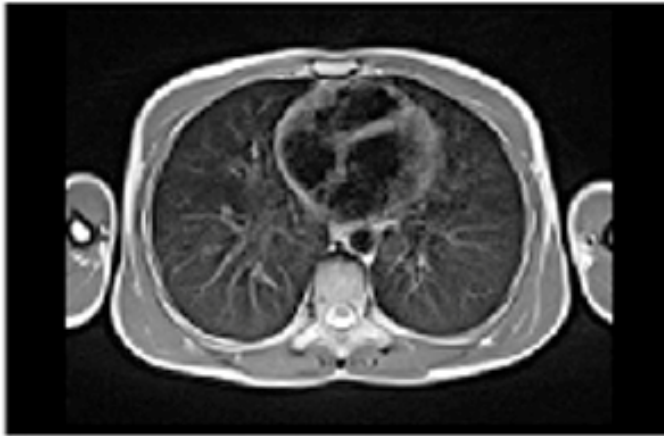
Low-field MRI measurements in healthy controls (n=9), participants recovered from COVID-19, (n=29) and participants with long COVID (n=25).
